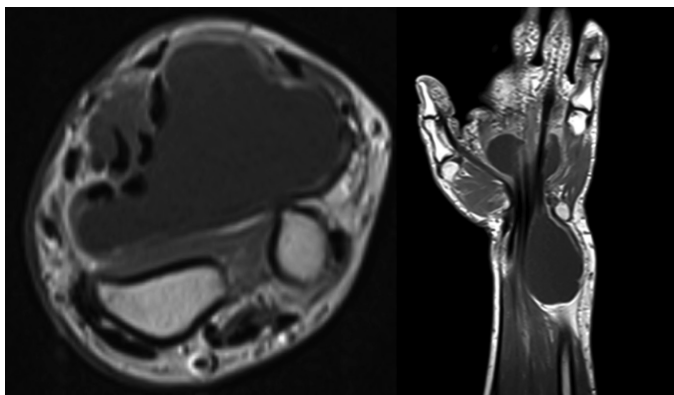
MRI images stated that 12x4 cm multiple fusiform shaped nodules were surrounding the flexor tendons and filling the carpal tunnel, hyperintense in T1 weighted isointense in T2 weighted images
